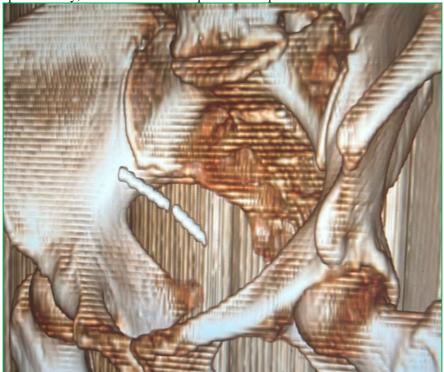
3D rendering of the abdominal CT showing a dense fragmented body in the pelvis.
